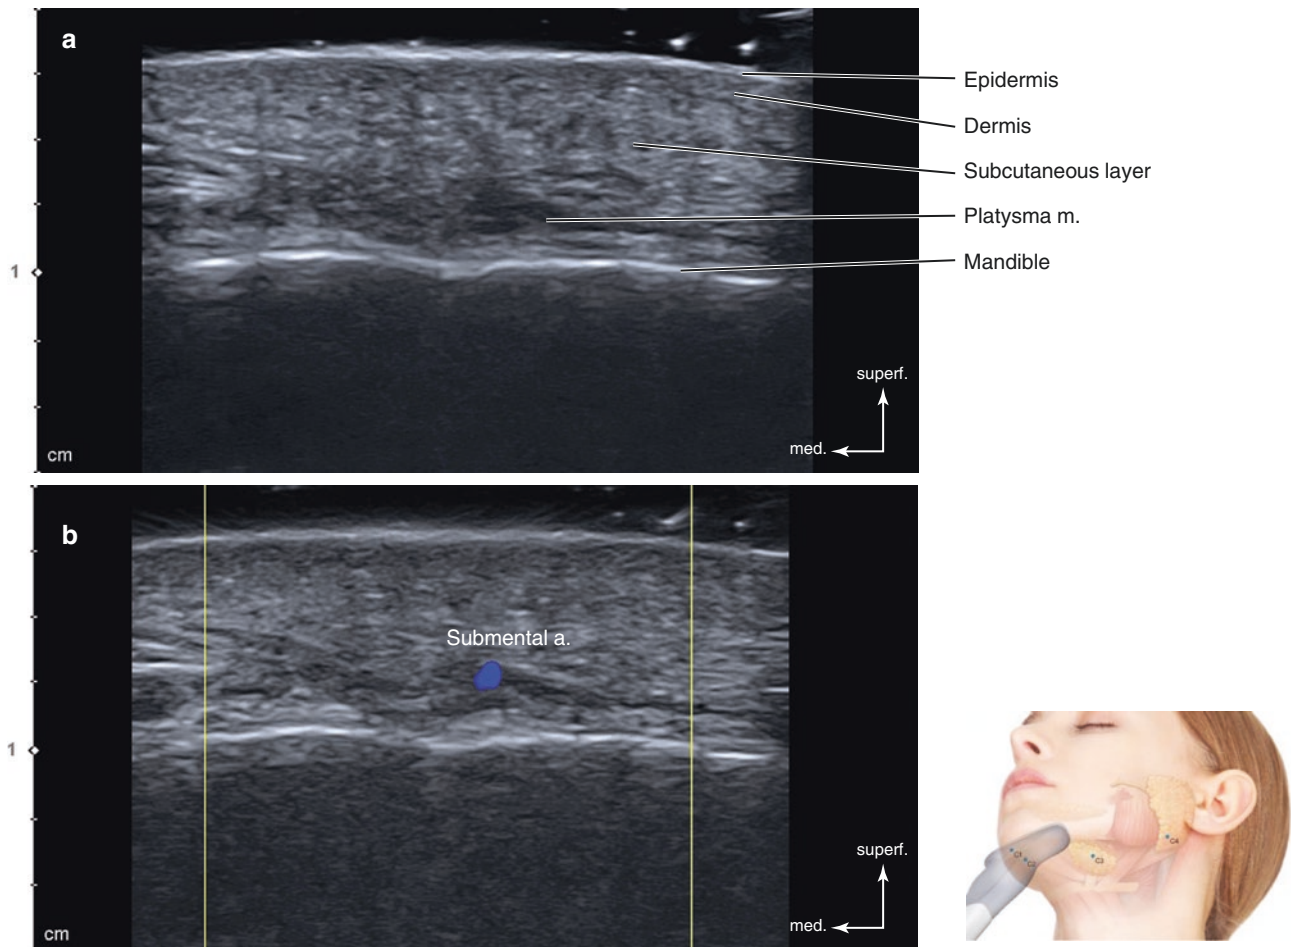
Ultrasonography of the gnathion (C1). (a) B mode (transverse view, 15 MHz by linear transducer) and (b) Doppler mode (transverse view, 15 MHz by linear transducer). (Published with kind permission of © Hee-Jin Kim 2020. All Rights Reserved)
